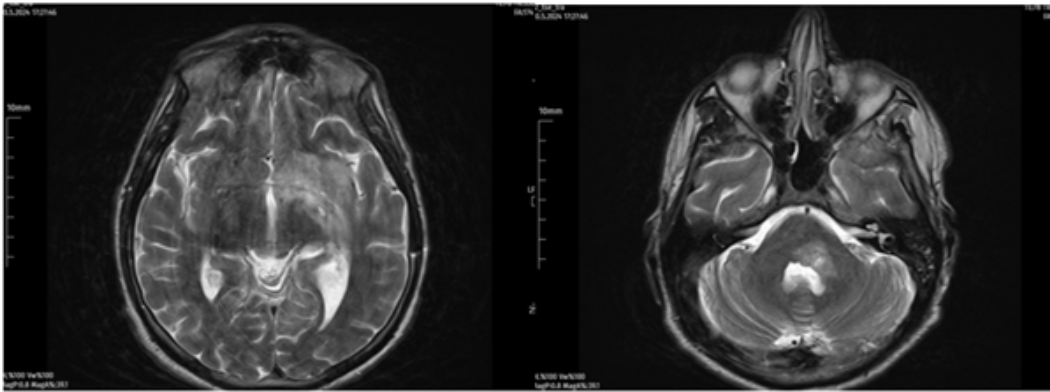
A lesion area is observed in the left superior region of the caudate nucleus, within the deep white matter in the periventricular area, showing hyperintense characteristics on T2-weighted imaging without significant diffusion restriction. Additionally, starting from the left lentiform nucleus and external capsule level and extending downward inferiorly, there are lesion areas on T2-weighted imaging, including hyperintense hemorrhagic foci and regions demonstrating acute diffusion restriction. Furthermore, starting from the midbrain level and extending inferiorly from the posterior of the superior cerebellar peduncle, there are lesion areas showing hyperintense signals on T2-weighted imaging, with some millimetric foci of acute diffusion restriction extending from the posterior pons to the left middle cerebellar peduncle and the left posterior region of the medulla oblongata.
